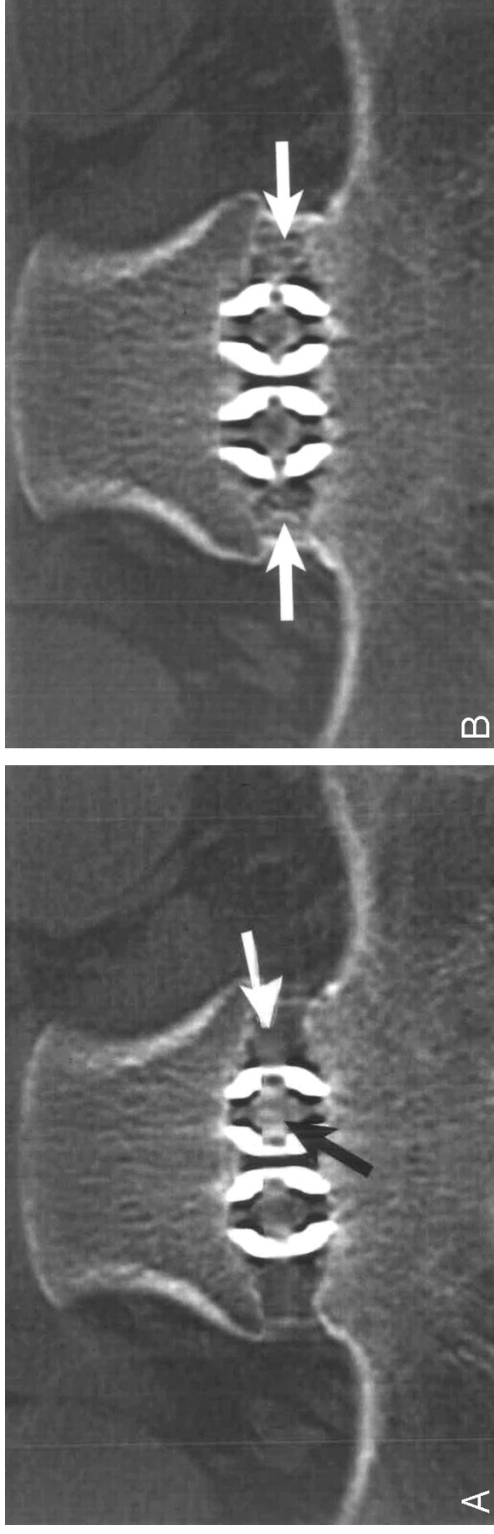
The normal progression of an interbody fusion in a coronal CT image at 6 months (A) and 10 months (B) in a 28-year-old woman. New bone formation is evident within (black arrow) and adjacent to (white arrow) (A). After 10 months, additional new bone formation, especially lateral to the fusion devices (white arrows) can be seen. Borrowed from the original source (Williams et al., 2005).
